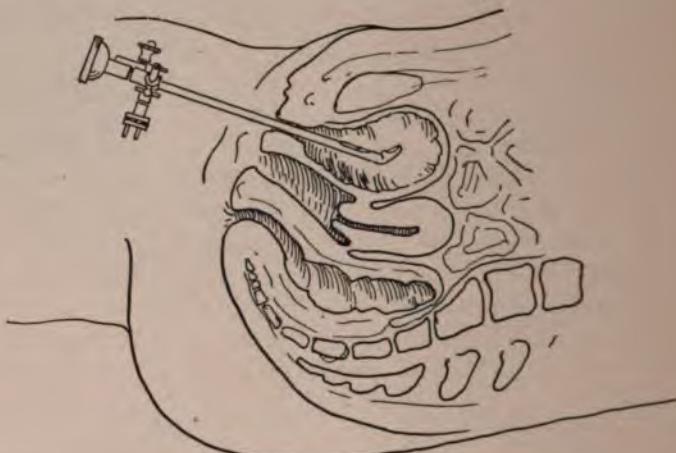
(197) METHOD OF INSPECTION BY NITZE CYSTOSCOPE.
